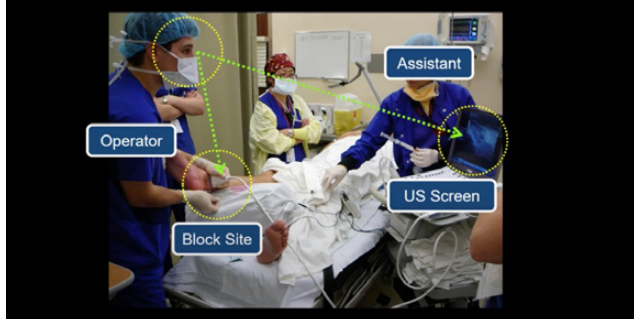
Correct operator orientation relative to ultrasound and patient. The operator should take a position that allows visualization of the patient, block site and ultrasound without turning of the body or head.
